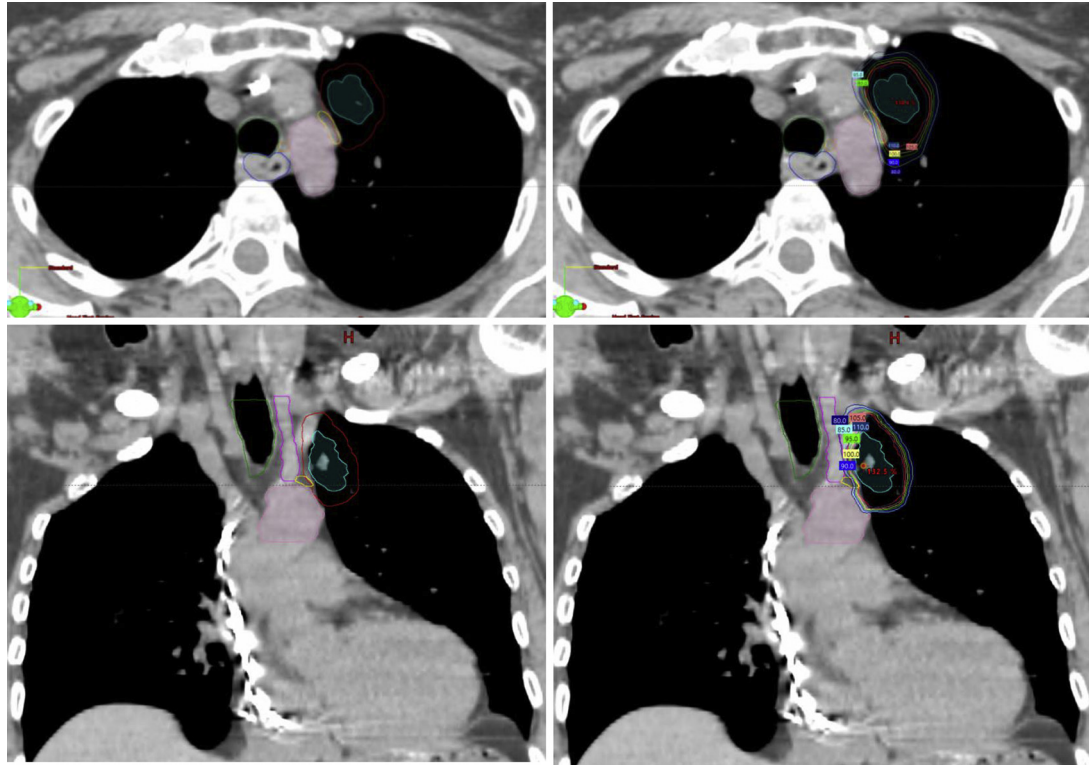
Case 1. PTV (red) delineated with segmentation of expected path of VN (yellow) and RLN (orange) (left column, upper and lower panels); dosimetric distribution of treatment plan targeting left upper lobe tumor treated with 55 Gy in five fractions (right column, upper and lower panels). Isodose curves displayed as a percentage of prescription dose. Windowing optimized for mediastinal structures underrepresents the true borders of the primary tumor. PTV; planning computed tomography with target volume; RLN, recurrent laryngeal nerve; VN, vagus nerve.
